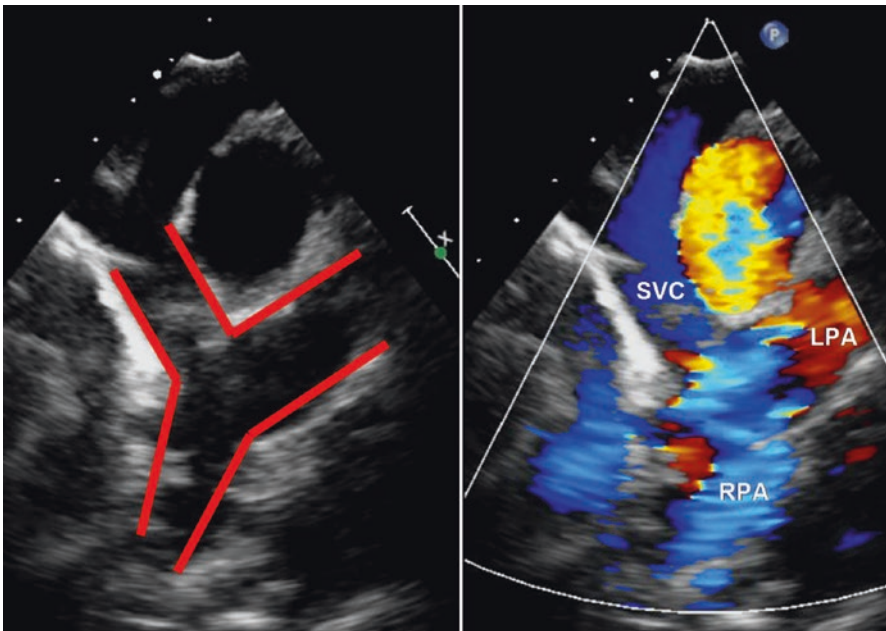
Superior caval to pulmonary artery anastomosis, outlined in red on the two-dimensional echocardiographic image. *SVC* superior vena cava, *LPA* left pulmonary artery, *RPA* right pulmonary artery
